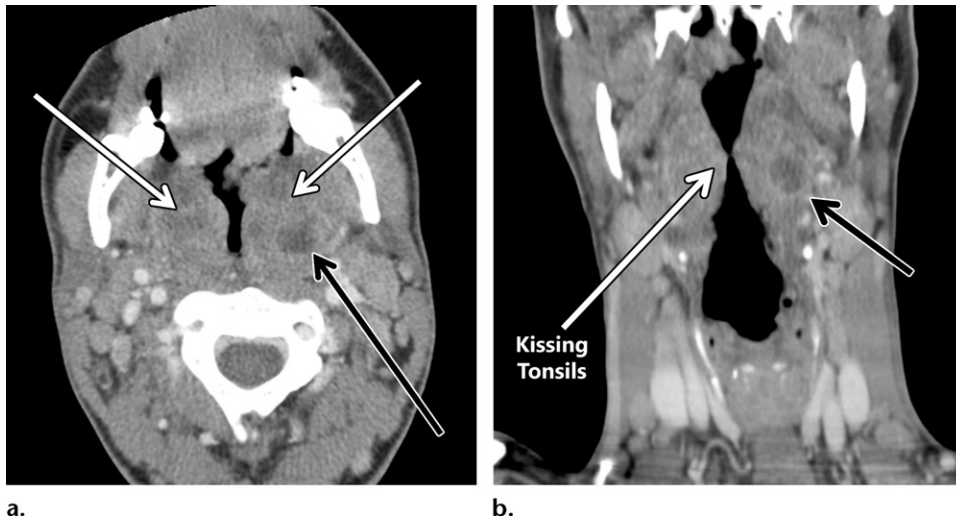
Tonsillitis with a peritonsillar abscess in a 21-year-old man who presented with a sore throat for 1 week, a fever, and worsening throat pain. Axial (a) and coronal (b) contrast-enhanced CT images show bilateral tonsillar enlargement (white arrows in a). The near-midline opposition is often called *kissing tonsils* (white arrow in b). A rim-enhancing cystic fluid collection posterolateral to the left tonsil represents a peritonsillar abscess (black arrow).
